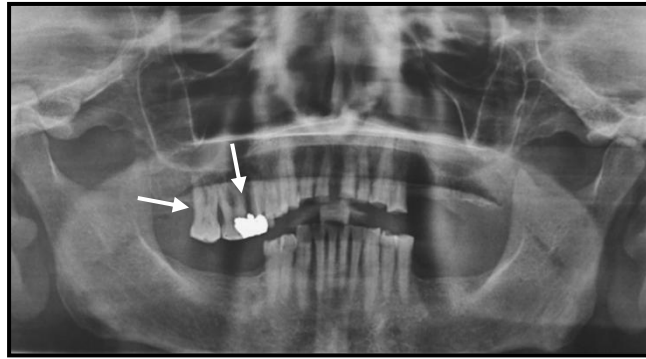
Panoramic X-ray before extraction of compromised teeth
